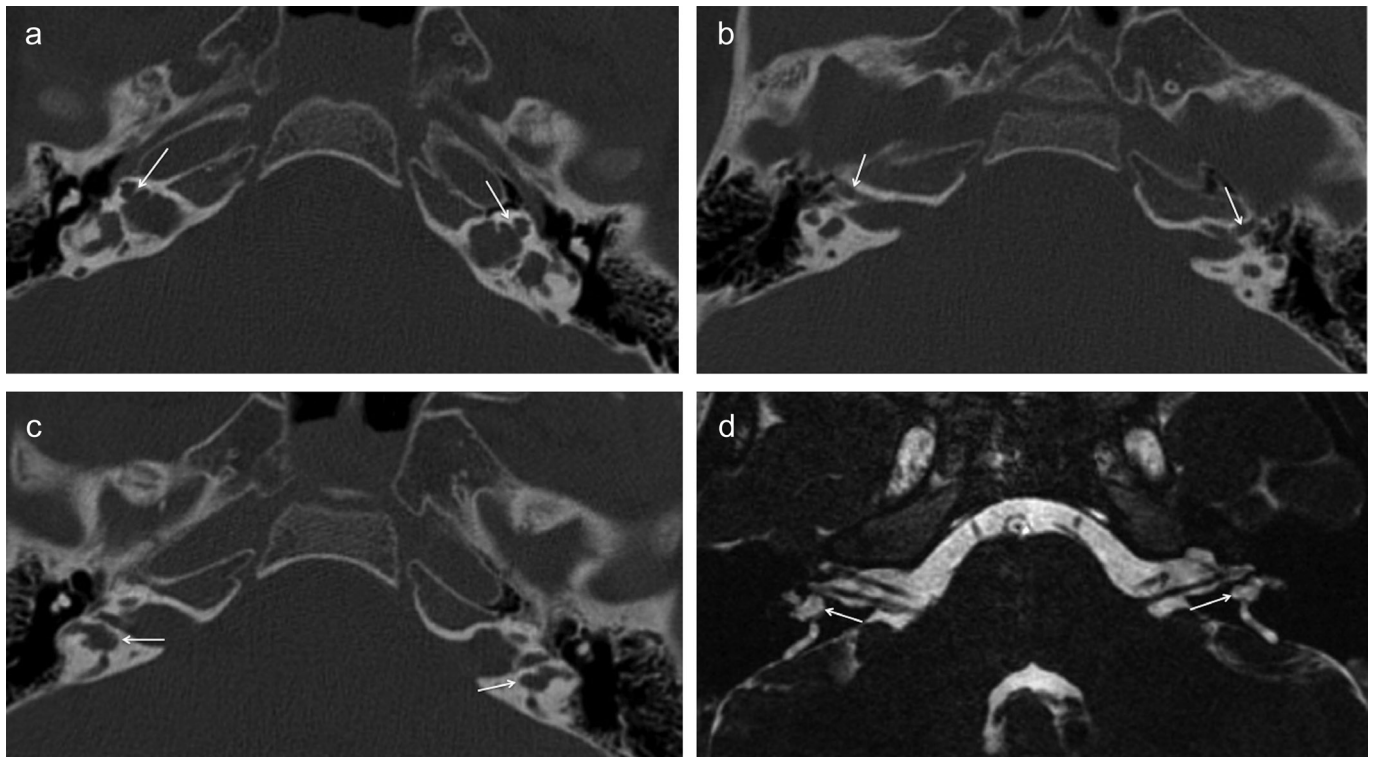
a-d. CT (a-c) and MR (d) images of a 3-year-old male XLD patient with IP-III anomaly. The images demonstrate bilateral bulbous IACs, absence of cribriform plate and modiolus, and a corkscrew-shaped cochlea with thickening of the ISS (a, arrows). Notice the subtle widening of the labyrinthine segments of facial canals bilaterally (b). Small cystic structures/diverticula (arrows) are seen adjacent to the vestibules (c, d).
